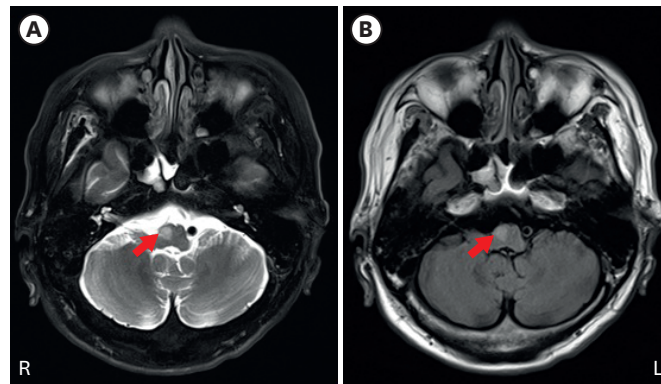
Red arrow indicates increased signal intensity in the right olivary nucleus which indicates hypertrophic olivary generation due to pontine hemorrhage in (A) Axial T2-weighted image, (B) Axial T2-FLAIR image.
